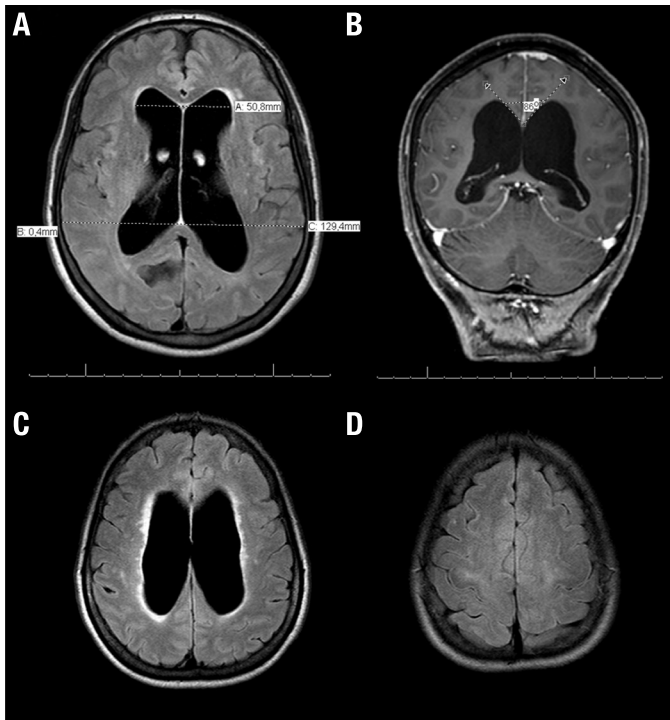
Neuroimaging in NPH (A) Axial FLAIR MRI scan showing a significant ventriculomegaly with increased Evans Index, the ratio of maximum width of the frontal horns of the lateral ventricles and maximal internal diameter of skull at the same level on axial CT or MRI images. In this case, Evans index is 0.39 (abnormal > 0.3) (B) T1-weighted coronal gadolinium-enhanced MRI scan showing reduced callosal angle. (C) Axial FLAIR MRI scan revealing enlarged lateral ventricles with bright signal in the surrounding white matter, suggestive of transependymal edema. (D) Axial FLAIR MRI showing narrowing of the sulci and subarachnoid spaces over the high convexity and midline surface in the frontoparietal regions.
